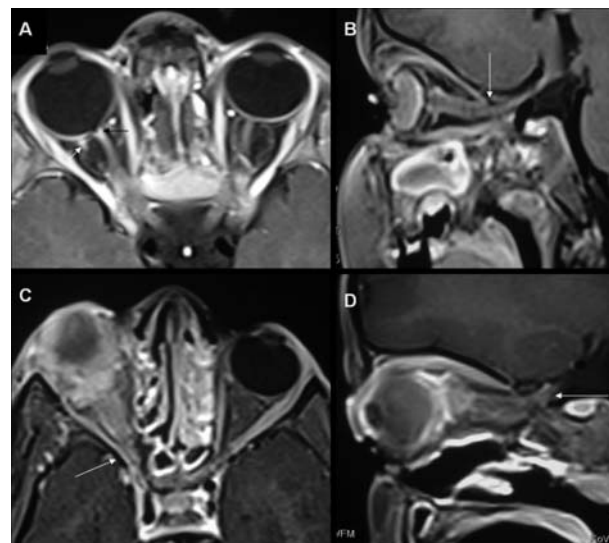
Post-contrast T1-weighted MRI demonstrating the proposed optic nerve based staging. (A) Stage 1: post-neoadjuvant chemotherapy (NACT) MR image (axial) showing enhancement of the most proximal right optic nerve (black arrow) for approximately 4 mm. A small linear residual tumour (white arrow) is noted temporal to the optic disc posterior to the staphylomatous globe. (B) Stage 2: post-NACT MRI (sagittal) showing enhancement of the optic nerve sparing the portion within the optic canal (arrow). Note the shrunken globe following chemotherapy. (C) Stage 3: Baseline MR image (axial) showing thickening and enhancement of the entire optic nerve including its intra-canalicular portion (arrow). (D) Stage 4: Post-NACT MR image (sagittal) showing marked thickening and enhancement of the entire optic nerve including its intra-cranial portion (arrow).
